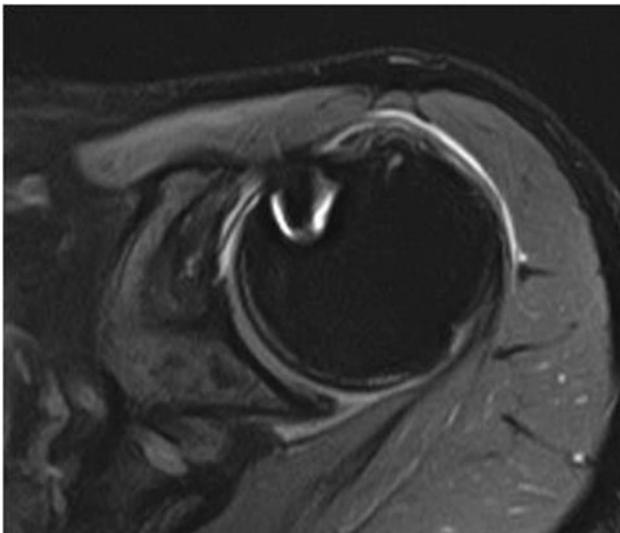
MRI transverse view of the full-thickness tendon tear of the case in Fig. 3
